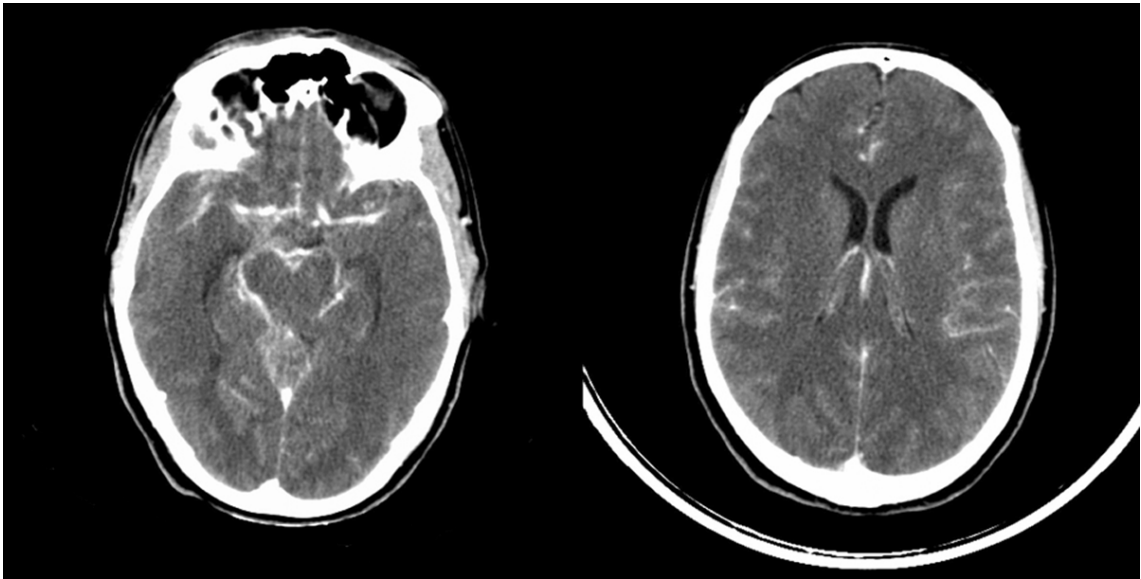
CT scan of the cranium one hour after the attempted RF-TR showing diffuse subarachnoid hemorrhage in the perimesencephalic cisterns and cerebral sulci bilaterally.
